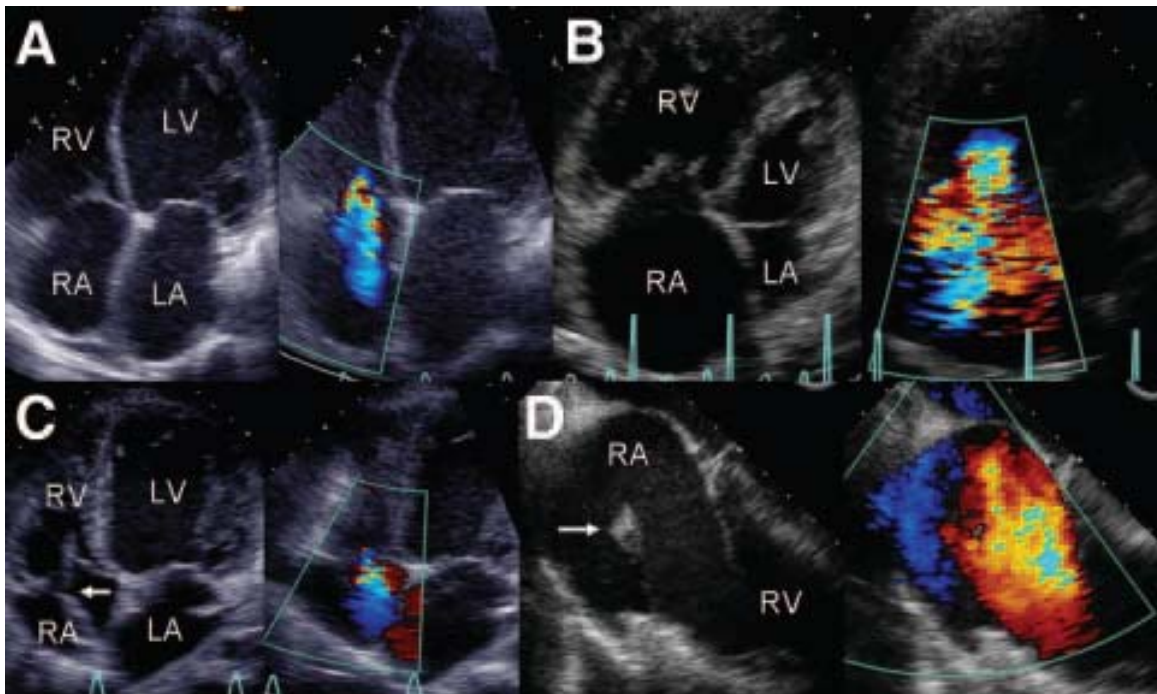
Echocardiographic appearance of tricuspid regurgitation (TR) from various pathologies. (A) Left ventricular (LV) dysfunction with mitral regurgitation and left atrial (LA) enlargement, with secondary right heart enlargement (mild TR). (B) An RV pacemaker lead present (arrow) (mild TR). (D) Cardiac contusion from motor vehicle accident with anterior papillary muscle rupture. The papillary muscle can be seen prolapsing into the RA with systole (arrow), resulting in torrential TR (Rogers and Bolling 2009).
